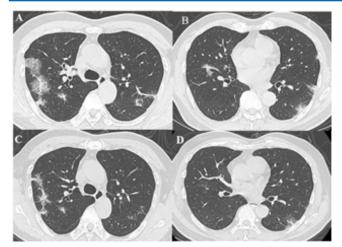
Images of a 63-year-old man with a history of full vaccination for COVID-19 and no comorbidities. He complained of recurrent fever and cough for a week. The highest temperature recorded was 38.5°C. (A-B) The initial chest CT scan reveals bilateral multifocal ground-glass opacity without consolidation. The CT severity score (CT-SS) was 6, indicating a typical appearance of COVID-19 based on the RSNA chest CT classification system. Transverse non-enhanced CT scan (C-D), obtained a week after infection, demonstrates residual reticulations.
